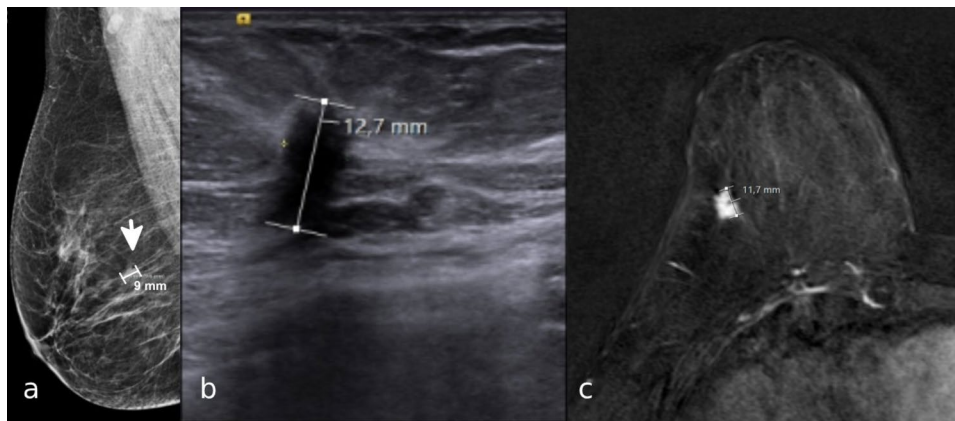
A 55-year-old female patient with a non-palpable tumor in the lower outer quadrant of her right breast had a lesion size of 9 mm on MMG (a), 12.7 mm on US (b), and 11.7 mm on MRI (c). The pathological result was invasive ductal carcinoma (invasive ductal carcinoma
